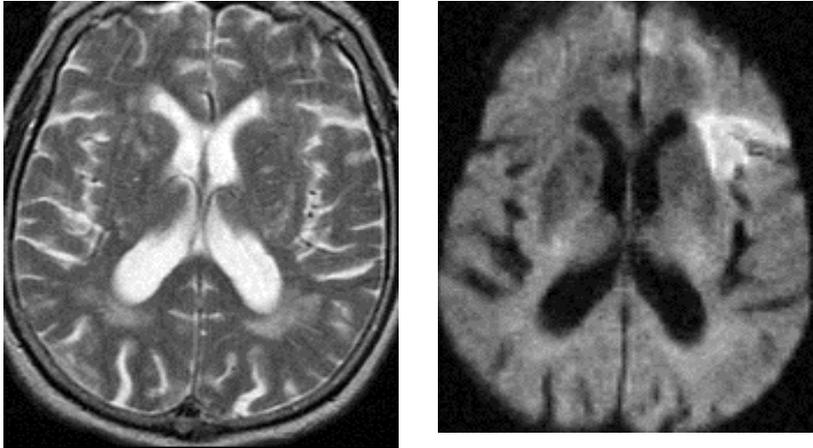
Acute brain ischaemia. A major clinical application of diffusion MRI has been acute brain ischemia. Images (*left*: conventional T2w-MRI) and (*right*: diffusion-weighted image) were obtained a few hours after the onset of aphasia in patient. The diffusion image clearly shows the infarcted tissue with an intense signal corresponding to reduced water diffusion in the ischemic territory.
